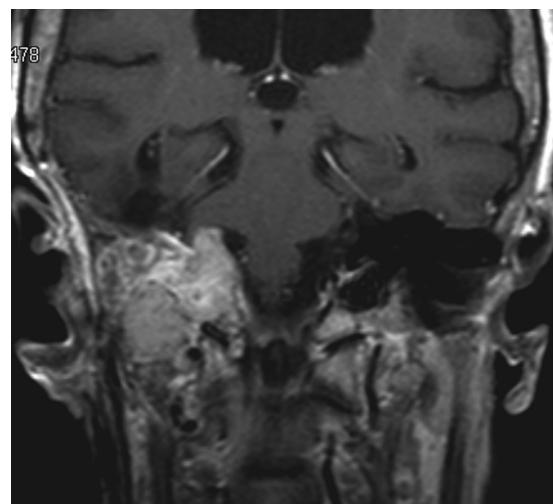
MRI two years after radiotherapy of the fifth case.
